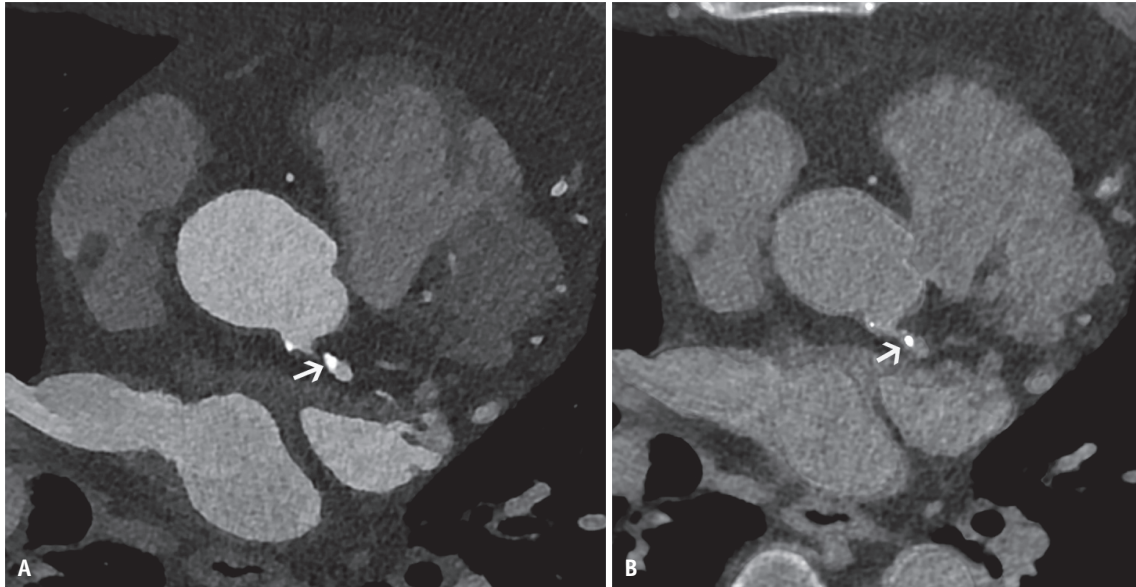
Calcium scoring from virtual non-iodine image. A: Coronary CT angiography from photon-counting CT in a 75-year-old female shows dense calcified plaque in the left main coronary artery (arrow) with moderate stenosis. B: Virtual non-iodine reconstruction (PURE Calcium) subtracts iodine but retains calcium (arrow), enabling calcium scoring without acquiring a separate non-contrast CT scan, thus reducing radiation exposure.
